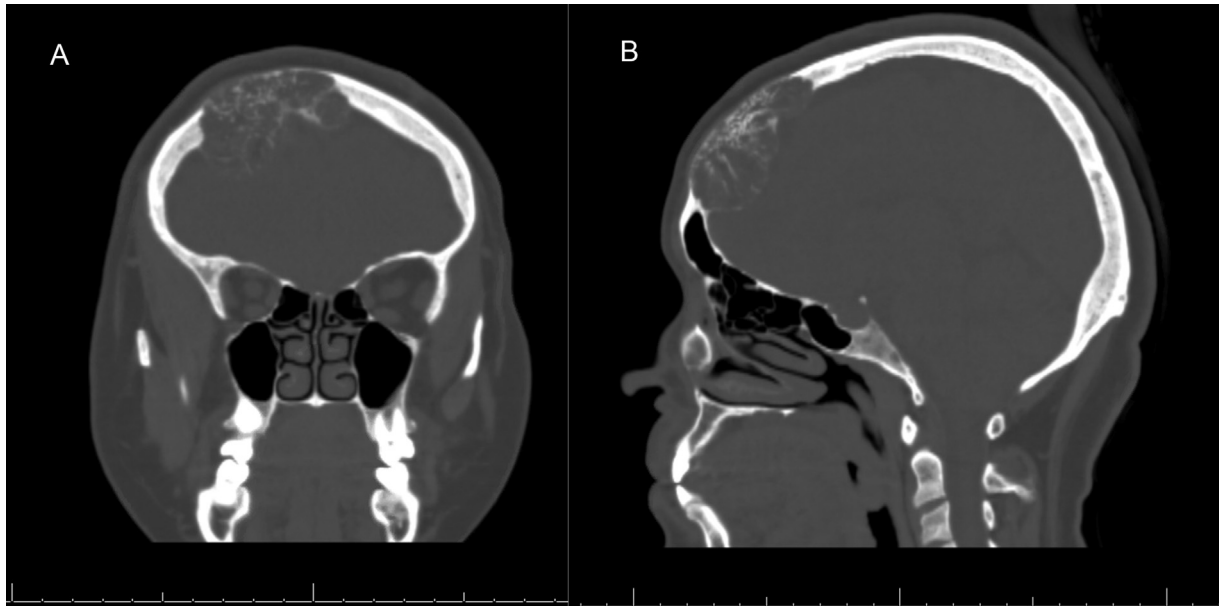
Noncontrast computed tomography (CT) preoperative coronal (A) and sagittal (B) images displaying well-circumscribed mass with trabecular thickening.
